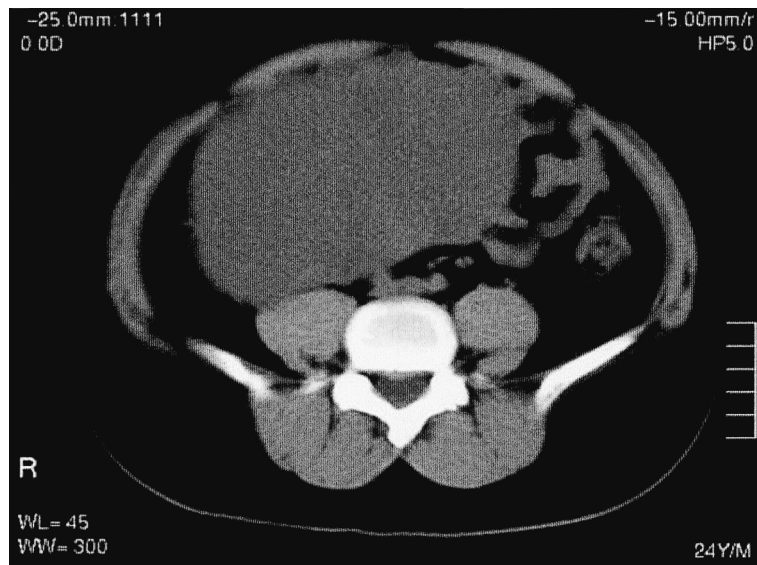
An abdominal CT scan shows a huge, homogenous, round mass in the right lower abdomen.
